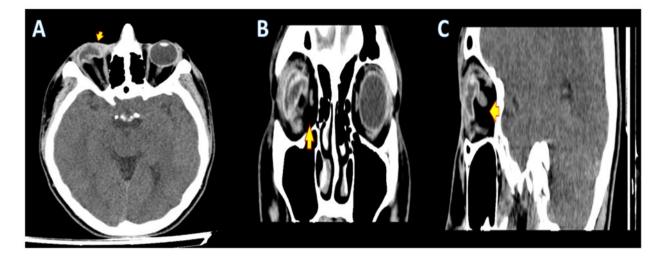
Axial (A), coronal (B) and sagittal (C) orbital CT images reveal right eye globe integrity is disrupted, perforated appearance and millimetric defect on the skin in the right infraorbital area (arrows).
